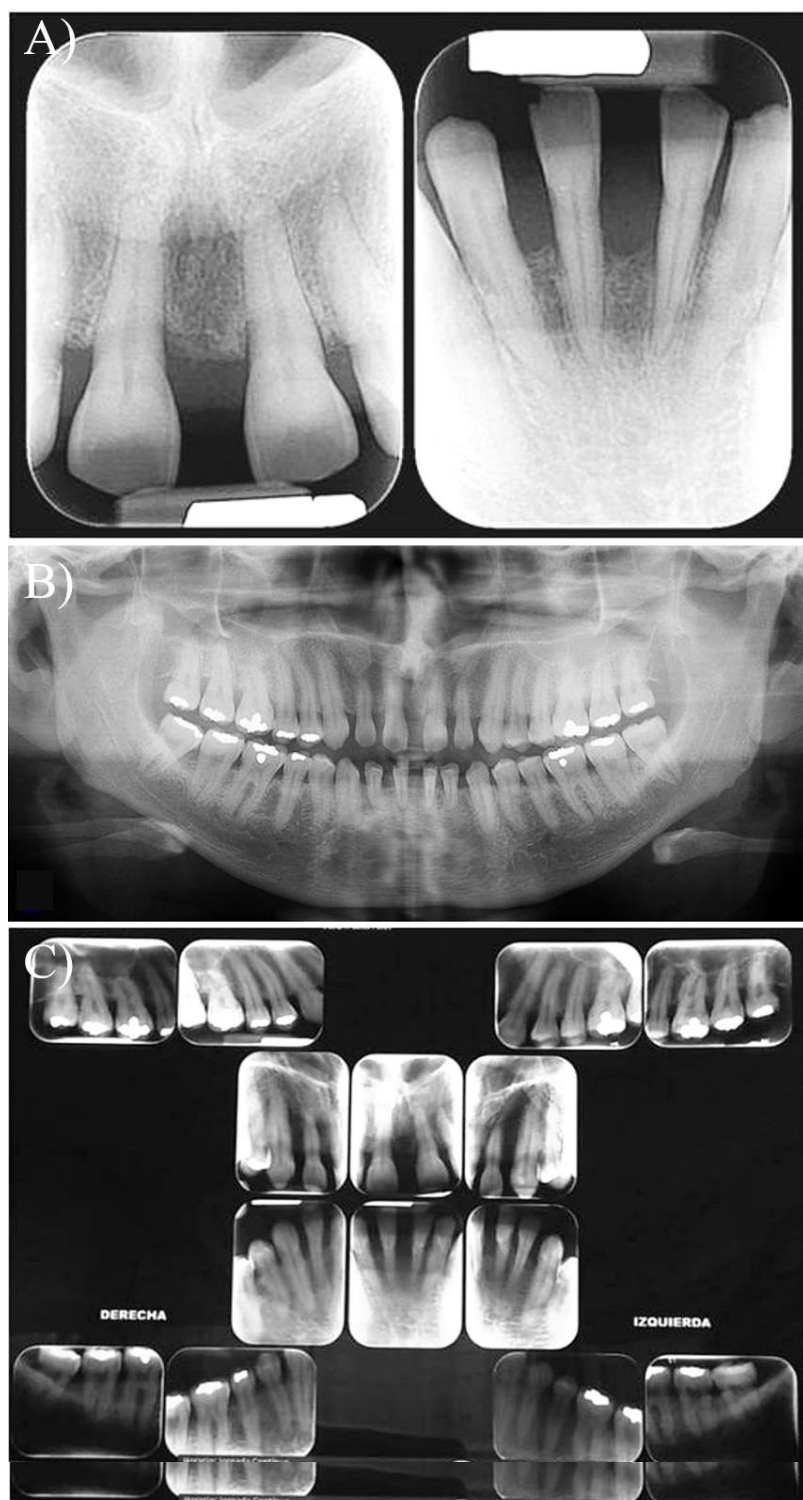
A) Initial panoramic radiograph, B) initial periapical radiograph of anterior teeth, C) initial periapical radiographs.
